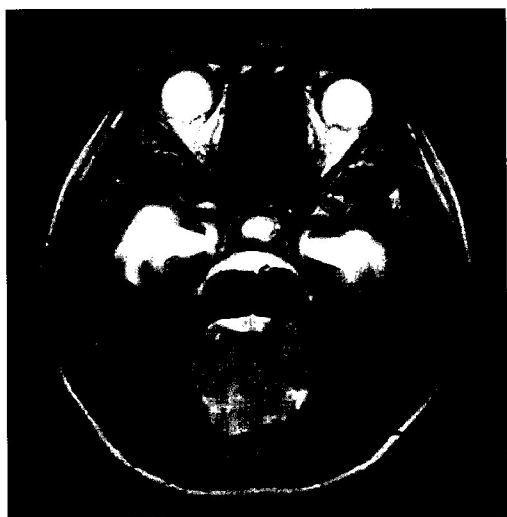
Preoperative T2-weighted, fast recovery and fast spin-echo MRI images show a large, lobulated mass lesion within the fourth ventricle, measuring approximately 60 mm x 45 mm x 40 mm, with heterogeneous enhancement. Note that the mass extends downward through the foramen magnum.
